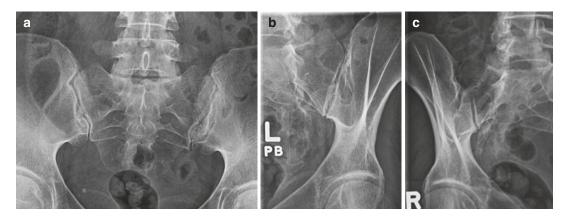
Normal radiographs of the sacroiliac joints, (a) AP, (b) left oblique and (c) right oblique
